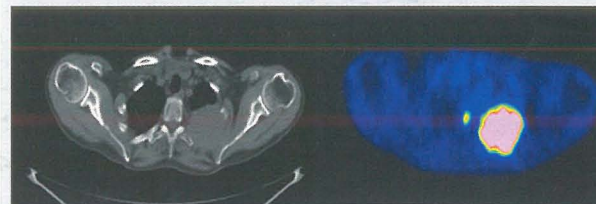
CT and PET image
